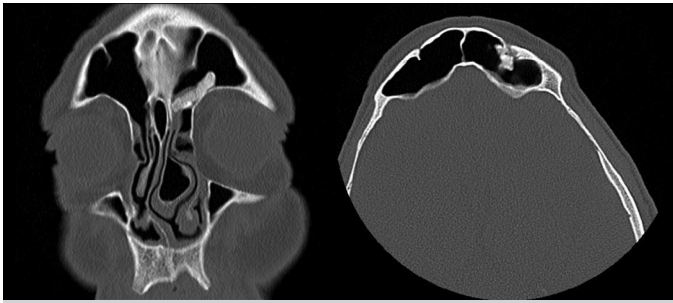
PNS CT images in coronal and axial sections
